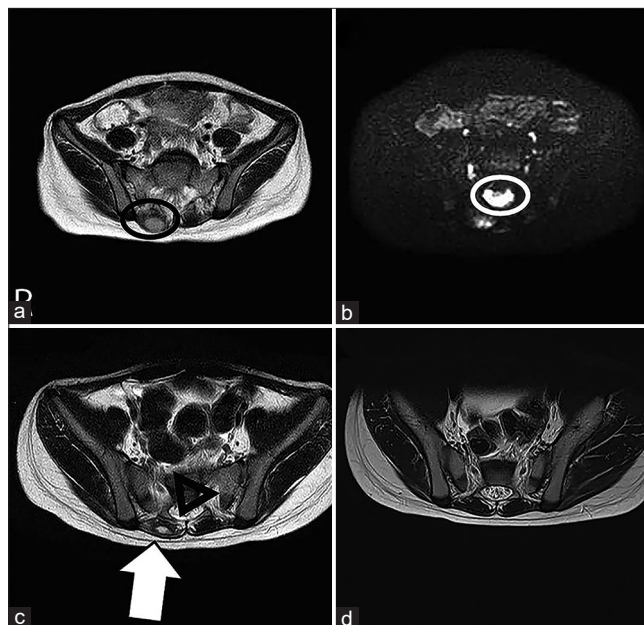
Lumbar to pelvic simple MRI images were taken of (a) and (b) on the 6th day of illness, (c) on the 13th day of illness, and (d) 1 month after discharge. (a) T2-emphasized image: A hyperintensity of marginalization is observed at 2 cm in the right erector spinae muscle (black circle). (b) Diffusion-weighted image: hyperintensity is observed in the posterior to the spinal canal from L4 vertebral body to the sacral region (white circle), (c) T2-enhanced image: paraspinal muscle abscess (white arrow) and epidural abscess (black triangle) tend to shrink, and (d) T2-emphasized image: it is confirmed that the abscess has completely disappeared.
